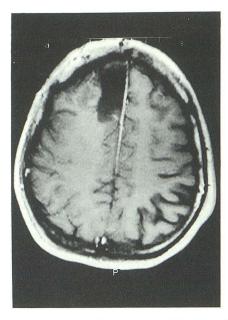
Axial enhanced T1-weighted MR image (600/20/2) obtained on first day after extirpation of a preoperatively nonenhancing low-grade glioma shows no enhancement along the resection margins, ie, no surgically induced blood-brain barrier disruption. Dural enhancement, however, of the falx cerebri, is present.
